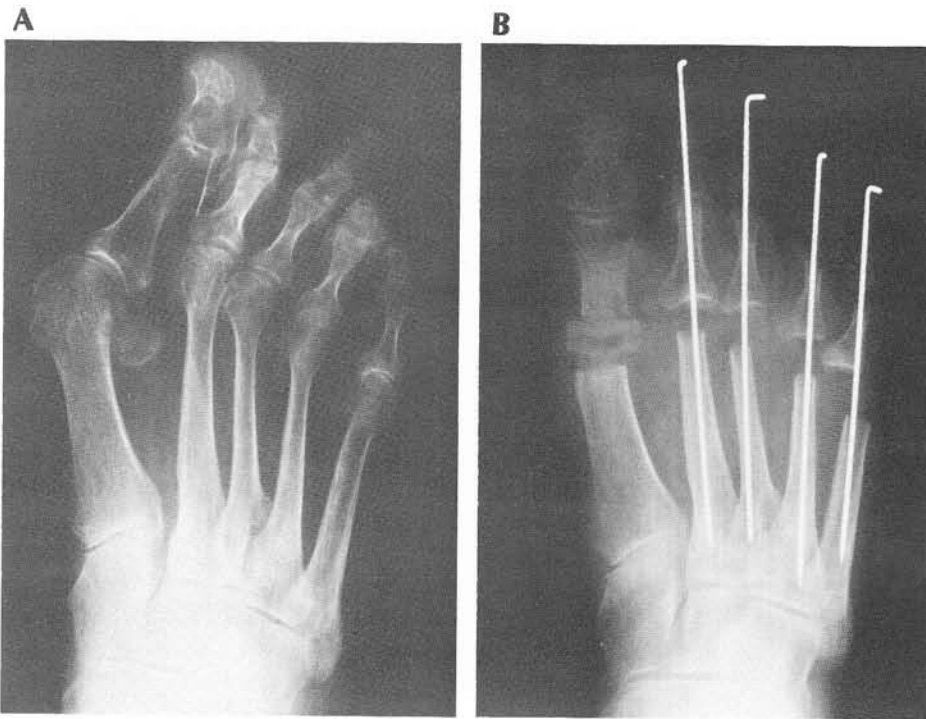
First metatarsophalangeal joint arthroplasty with insertion of Swanson silastic total implant. A. Preoperative and B. postoperative x-rays.
